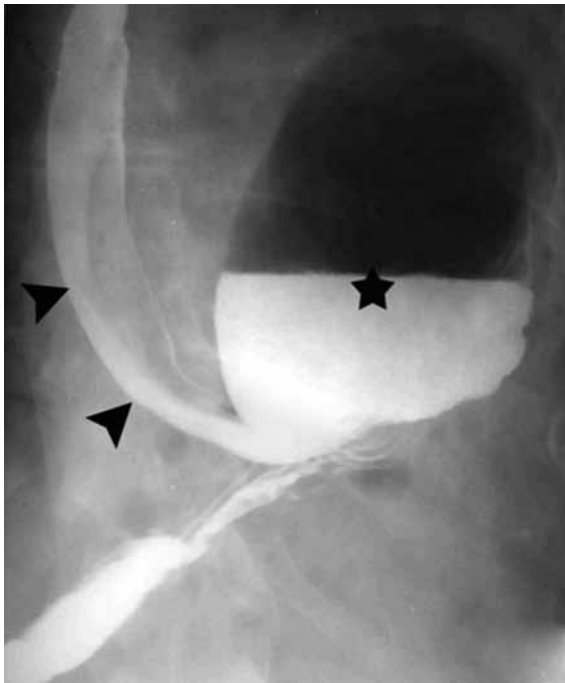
An image showing the stomach (star) and esophagus (arrowheads) of a patient shown by barium-contrasted X-ray.
